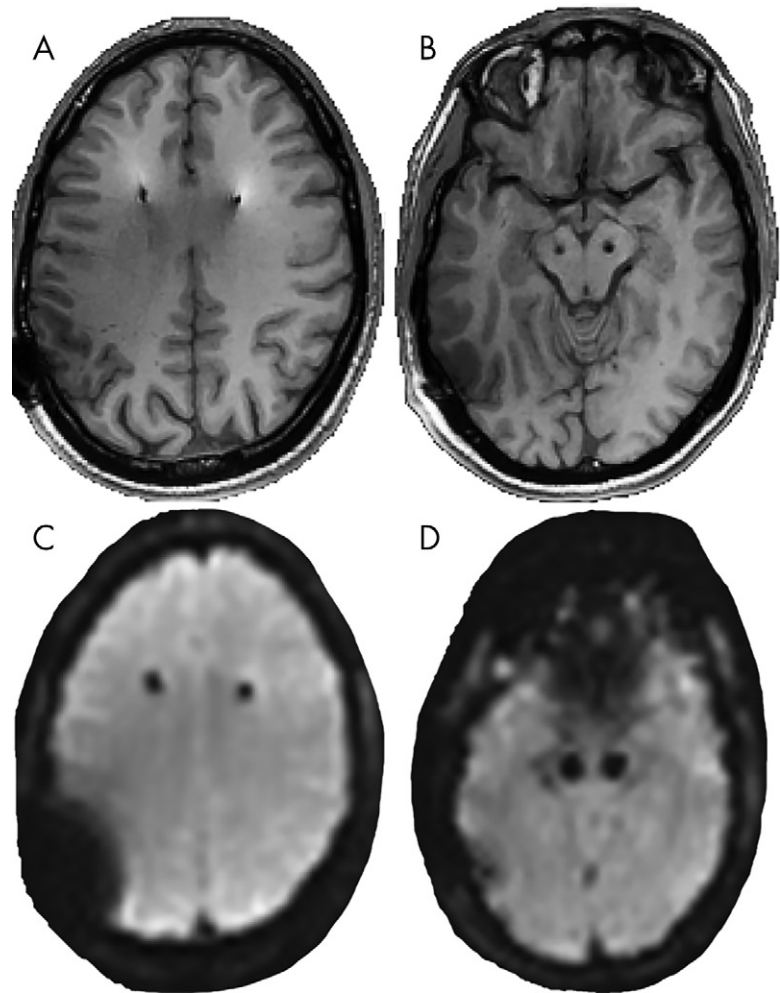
MRI of deep brain stimulation (DBS) device at 3 T. Select images from axial, A, B, three-dimensional spoiled gradient-recalled MRI and, C, D, gradient-recalled echo–echo-planar imaging in participant receiving DBS show the DBS hardware artifact at the level of, A, C, frontoparietal and, B, D, electrode contact artifacts.
